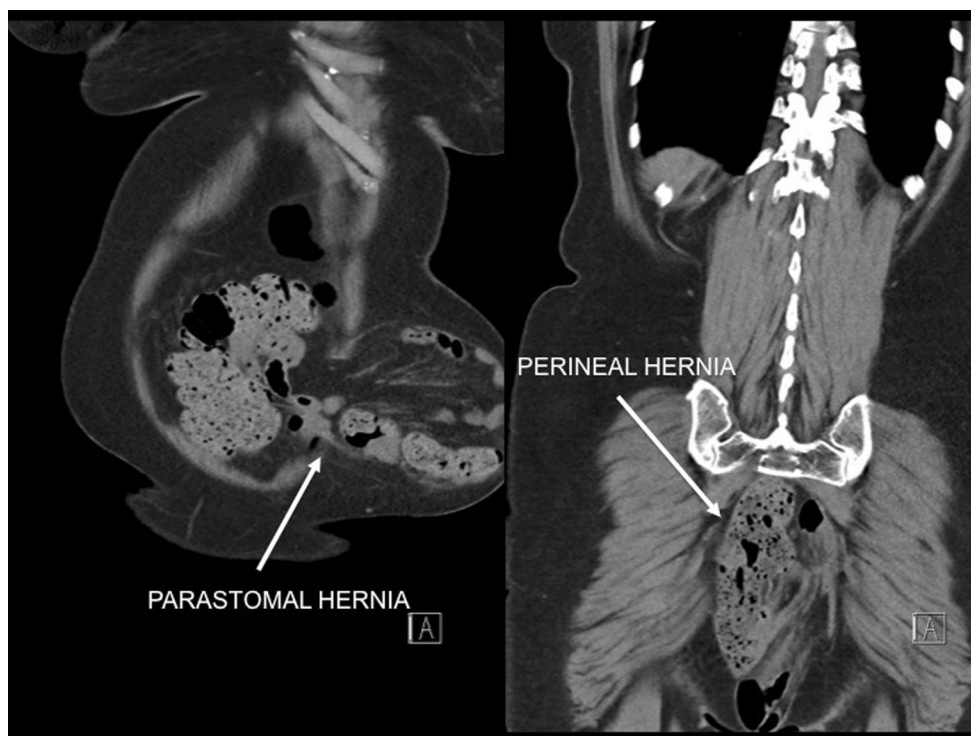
Preoperative abdominopelvic computed tomography scan
